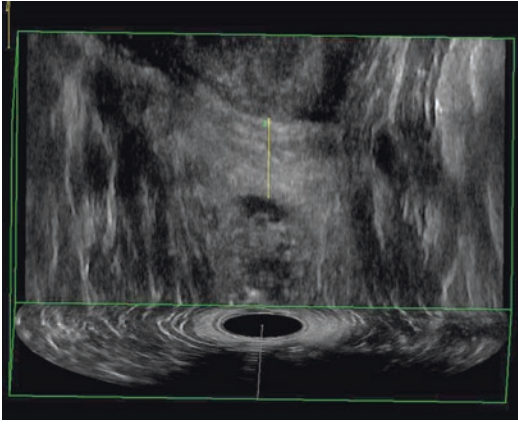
3D endoanal ultrasonography performed by BK 2052 probe. Measurement of anterior length of the external sphincter in the coronal plane
